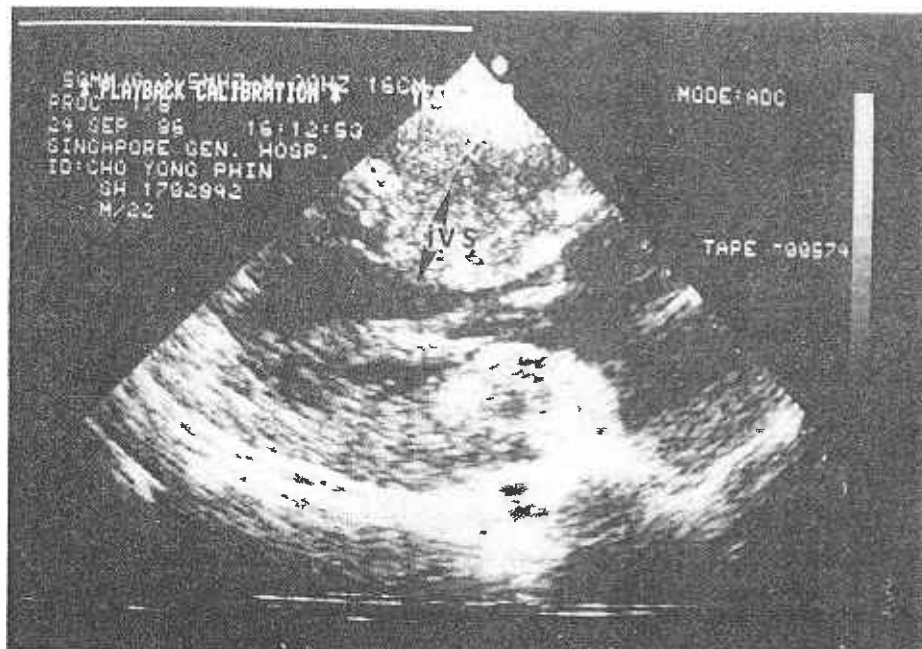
Apical 4-chamber view (2D Echo) again showing the thickened ivs (arrowed) as well as the dilated left atrial cavity.
